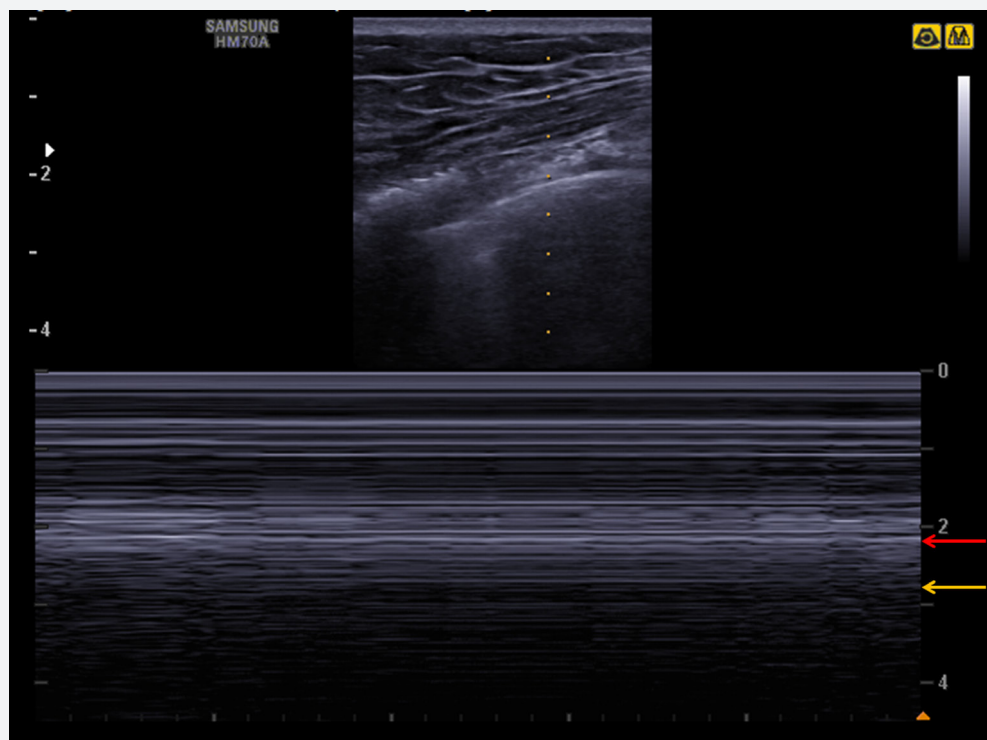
Lung ultrasound using the Samsung HM70A. During the follow-up examination, the pneumothorax was still visible. As seen in M-Mode, the delimitation of the pleura (red arrow) and the stratosphere sign (yellow arrow) is an indication that the pneumothorax still existed.
